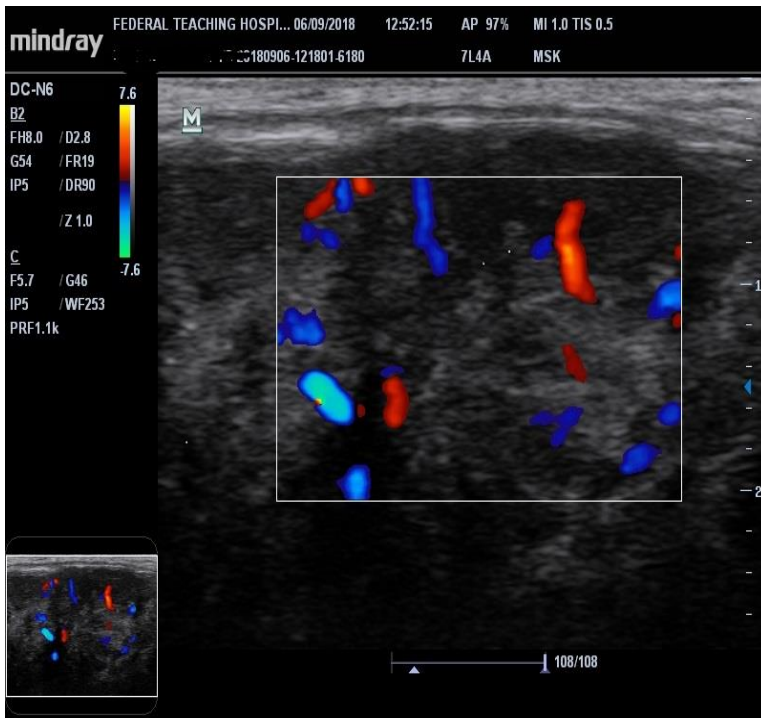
Colour Doppler assessment showing increased colour vascular flow within the mass.
